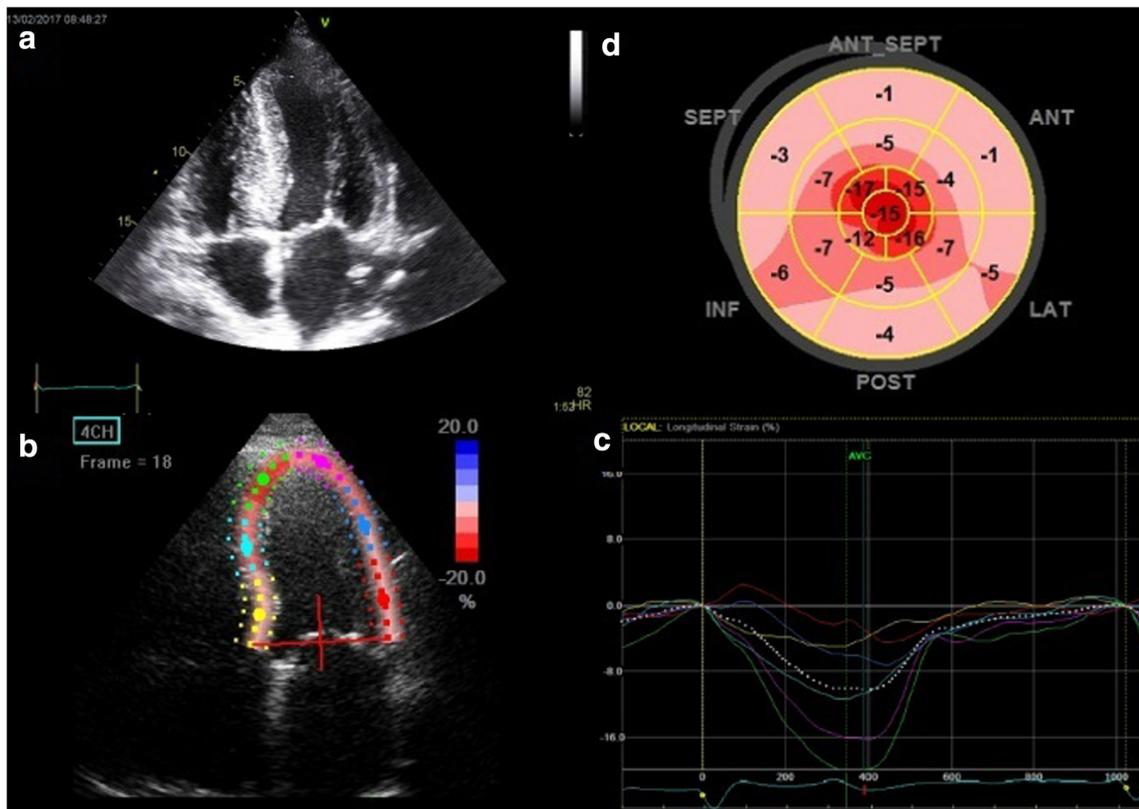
a An apical 4-ch view showing an hypertrophic left ventricle with “granular sparkling” aspect, consistent with amyloidosis suspicion. b Delineation of the six segments composing the region of interest for strain acquisition. c Strain curves showing regional differences of LV LS in a
